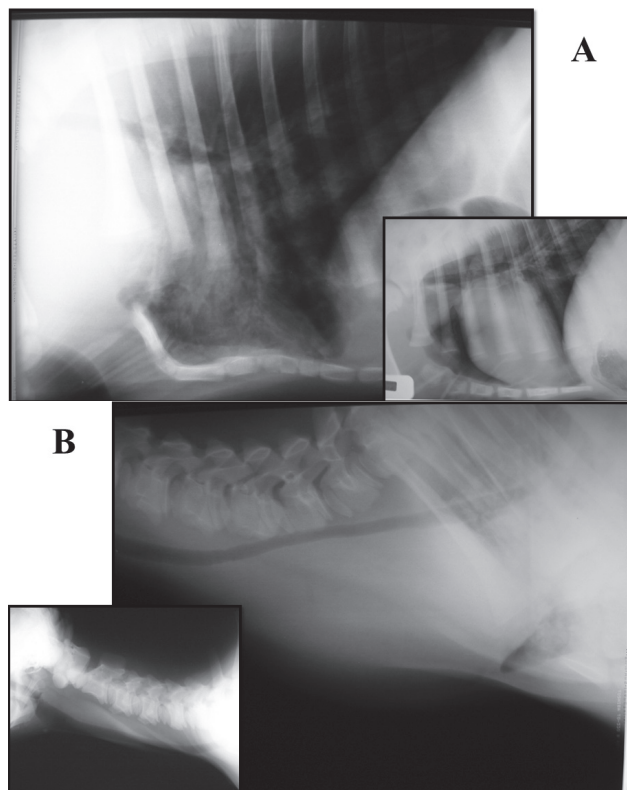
X-ray image of the calf with cervical ectopia cordis at 5 days of age. Lateral chest X-ray shows the displacement of the heart from the pleural cavity along with a sternum deformity (A). Lateral cervical X-ray examination revealing the elevation of the trachea attributable to the cervical mass (B). Insets of A and B are lateral X-ray images of a normal calf of the same age.
